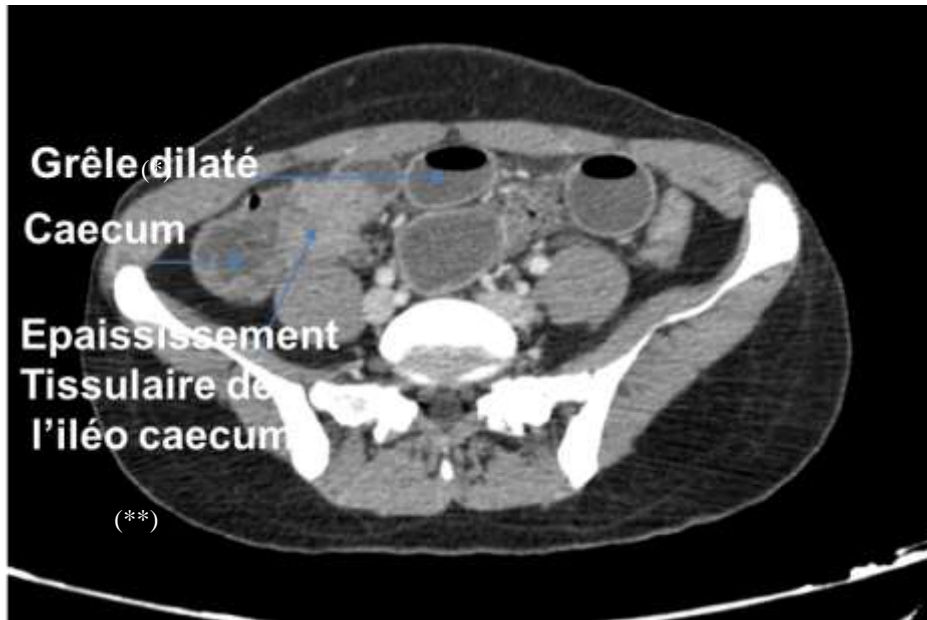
Axial plane CT scan showing ileo-caecal stenosis with upstream dilatation.
